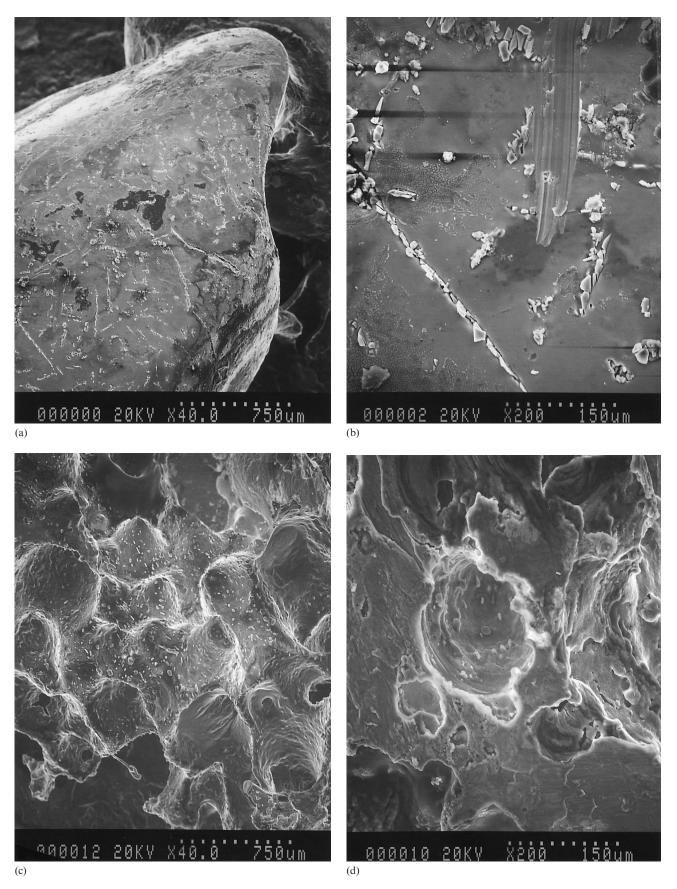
Calcium surface activated by abrasion with sand in the stirred experiment (a), (b). In ultrasonic conditions (c), (d).
